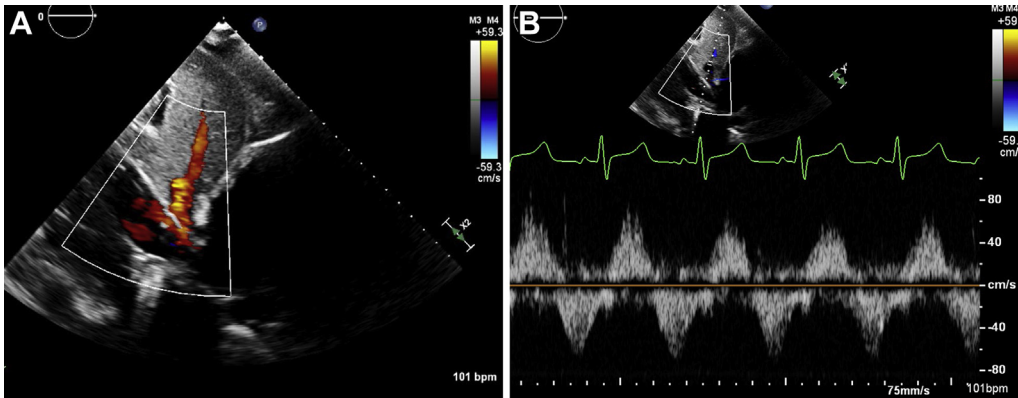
(A) Subcostal view of inferior vena cava (IVC) showing extracorporeal membrane oxygenation inflow cannula at the junction of the IVC and right atrium with reversal of blood flow through hepatic veins, indicating increased right atrial pressure. (B) Pulsed-wave Doppler over hepatic vein showing biphasic pattern with retrograde systolic flow reversal supporting severe tricuspid regurgitation and possible right ventricular dysfunction.
